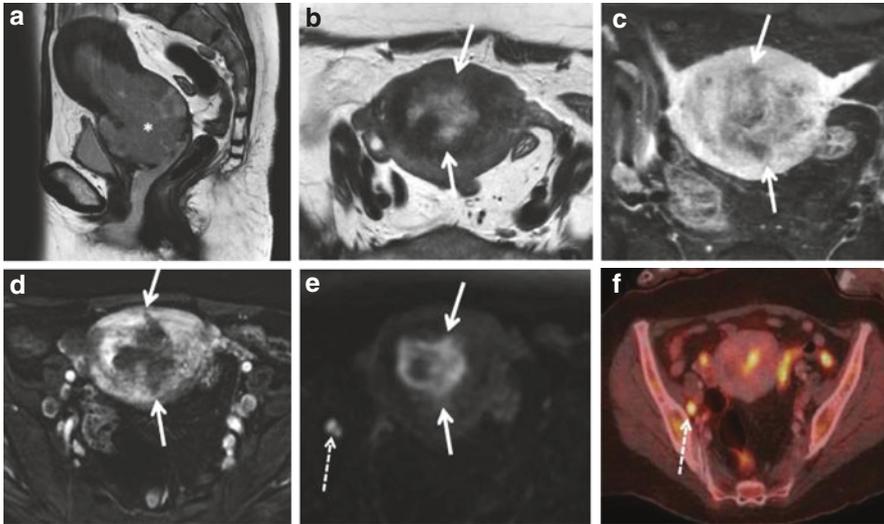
Patient with advanced endometrial cancer: (a) Sagittal T2-weighted MRI shows large mass in the endometrial cavity with gross cervical invasion (asterisk). (b, c) Transverse T2-weighted and contrast-enhanced T1 image shows multifocal deep myometrial invasion (arrows). (d, e) This is better appreciated at DCE-MRI and DWI due to the high tumor-to-background contrast (arrows). DWI also allows the depiction of a bright right iliac lymphadenopathy, confirmed by FDG-PET/CT (f, dashed arrow)
